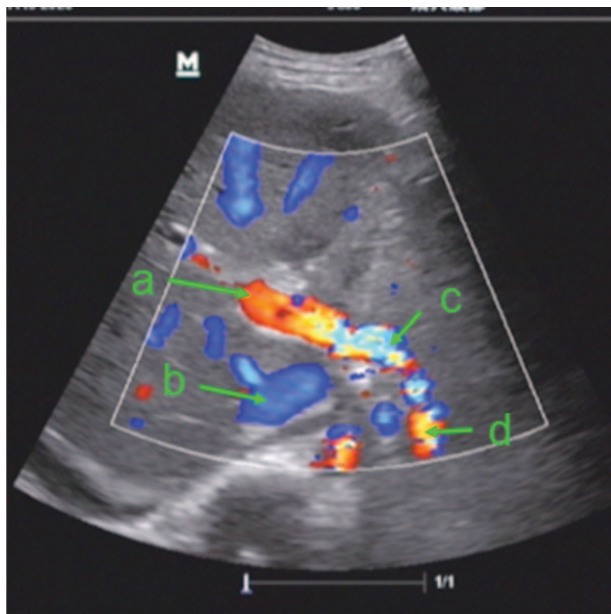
One week after operation, color Doppler ultrasound shows the signal of blood stream from proper hepatic artery into portal vein. a: portal vein, b: inferior vena cava, c: blood stream from proper hepatic artery into portal vein, and d: proper hepatic artery.
